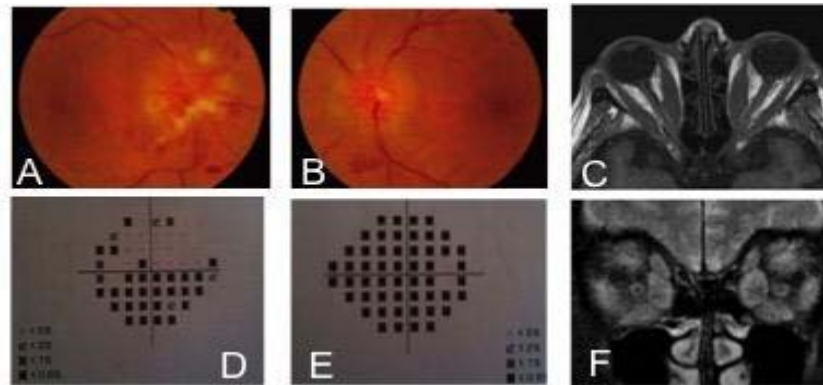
Fundus of the right eye (A) and left eye (B) showing papilledema, venous engorgement, hemorrhages adjacent to the optic disk margins. Multiplanar magnetic resonance imaging (C-F): C. Axial T1 WI showing bilateral extraocular muscle belly enlargement with sparing of anterior tendon with reduced attenuation representing fatty infiltration. (F) coronal T2WI with fat suppression. The enlarged muscles with increased T2 signal intensity correlates to the severity of disease and the risk of optic nerve compression, with crowded apex in the extreme posterior orbital slices. (D-E) Humphrey 30-2, visual field with decreased sensitivity in both eyes.
